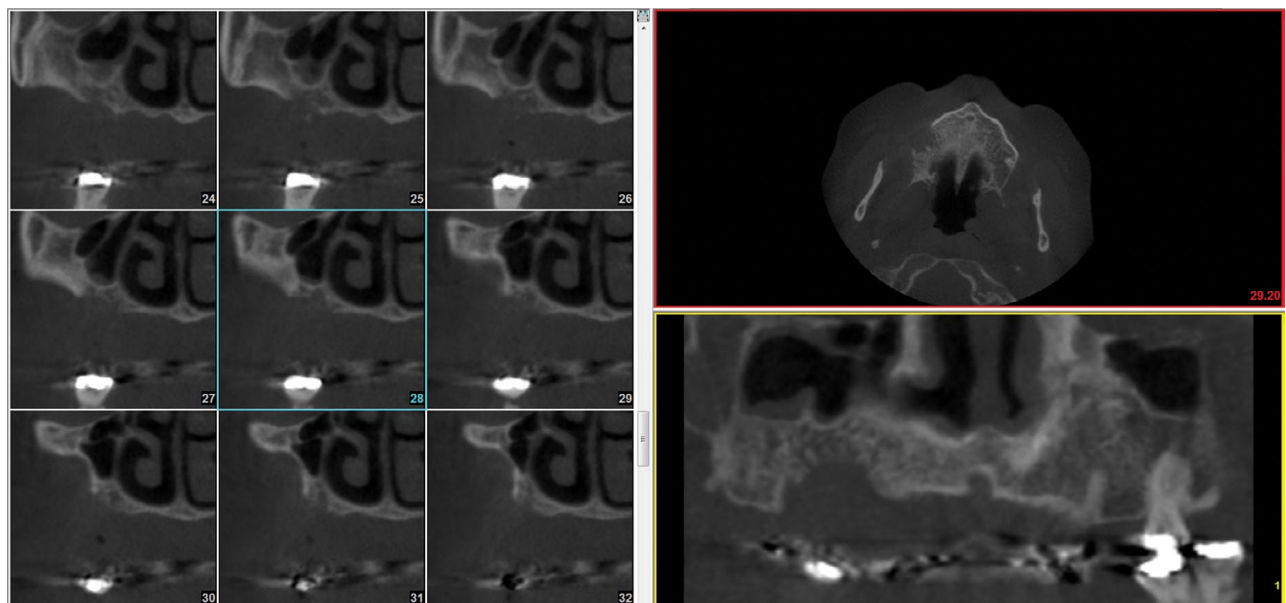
Cone beam shows significant destruction of right maxillary alveolar process.
